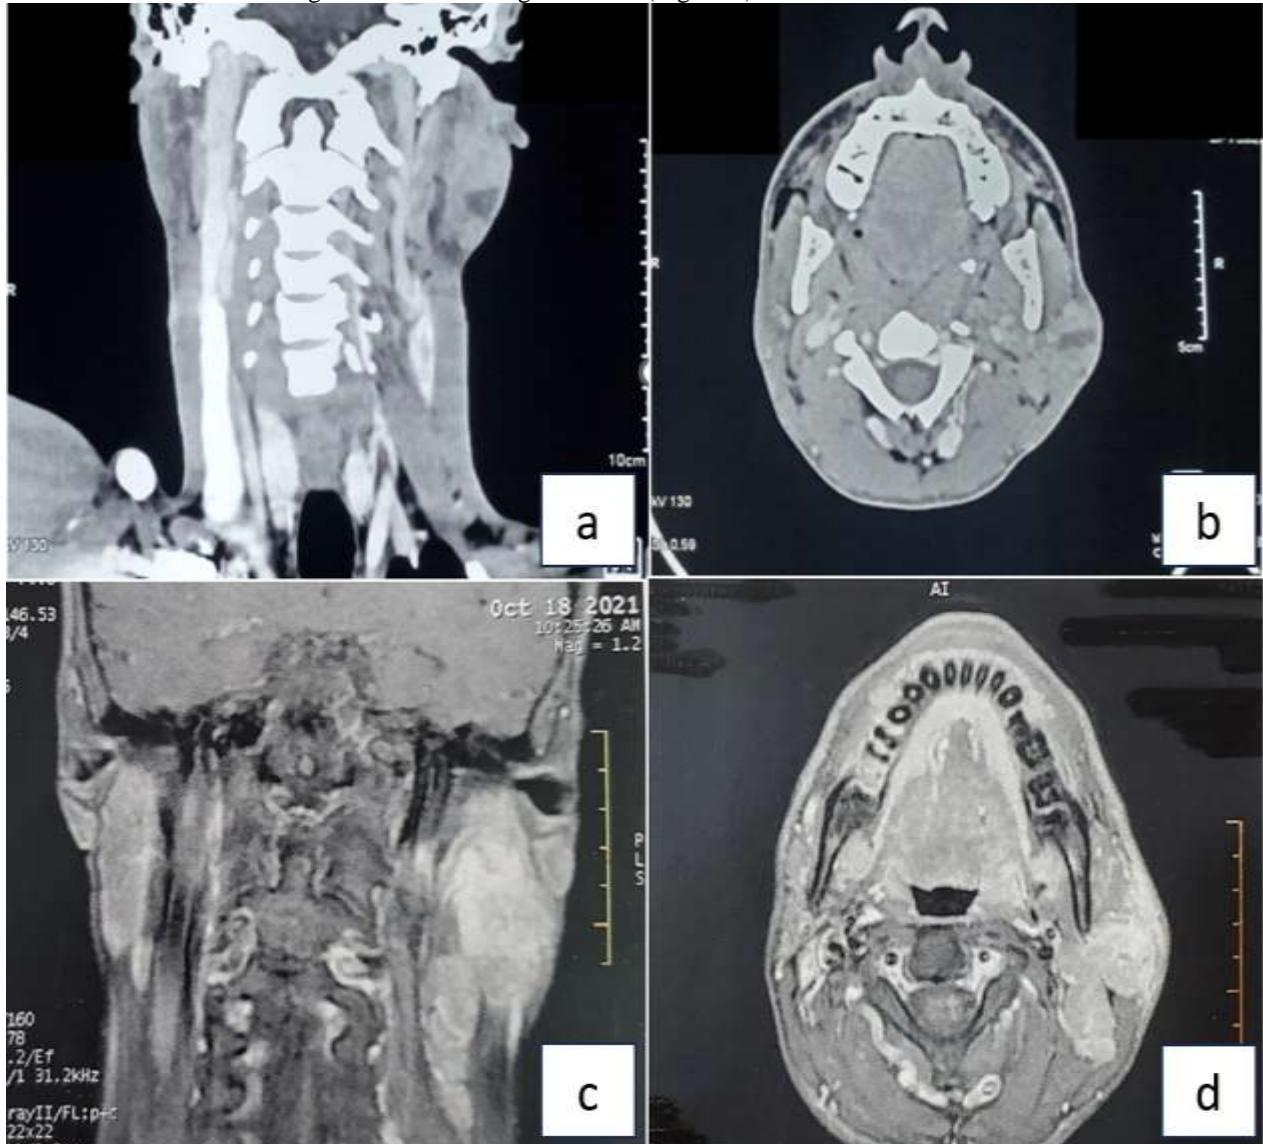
CT (a,b) and MRI (c,d) images showing a tumor in the left parotid gland.
